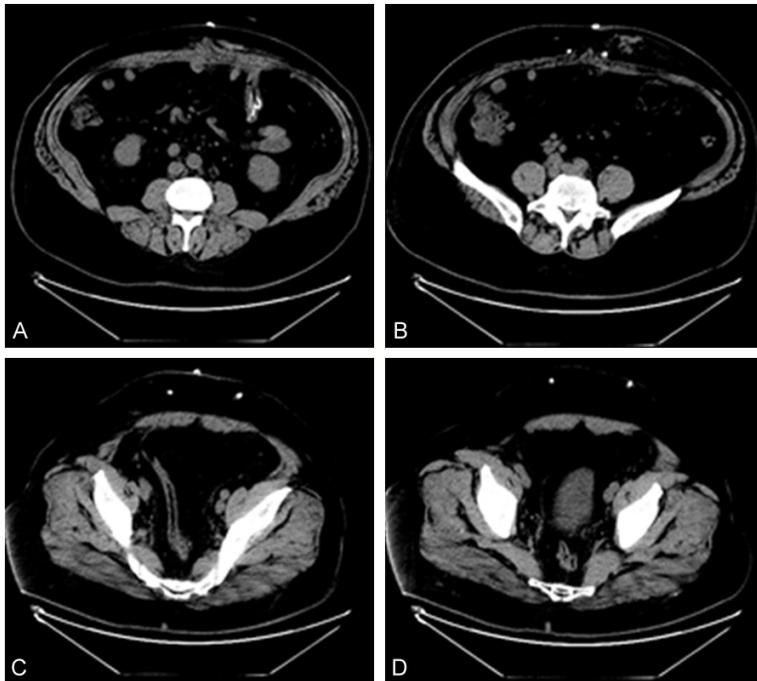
CT image of patient one week after surgery. (A) No significant infiltration of rectus abdominis fat; (B) No obvious dilatation and free ascites in abdominal cavity; (C, D) Above and below the midpoint of the connecting line between umbilicus and pubic symphysis, the bottom of the aponeurosis of the external oblique abdominal muscle and the front of the transverse fascia of the abdomen, abdominal cavity with no fluid and no thick-walled tubular shadow.
